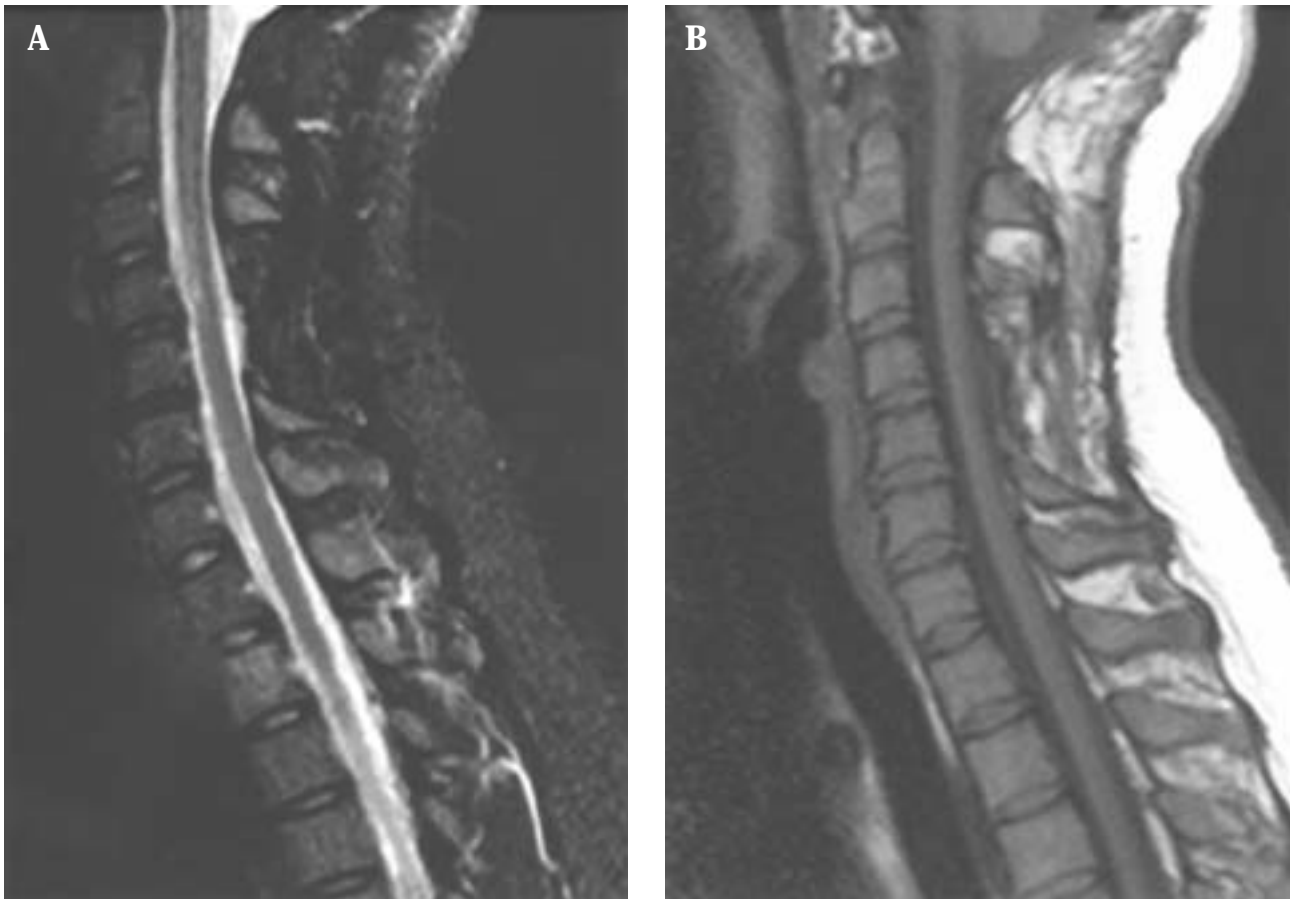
Postoperative unenhanced sagittal magnetic resonance images of the craniocervical junction and cervical spine (12 months after surgery) demonstrate reduction in syrinx size: (A) T2-weighted; (B) T1-weighted.
